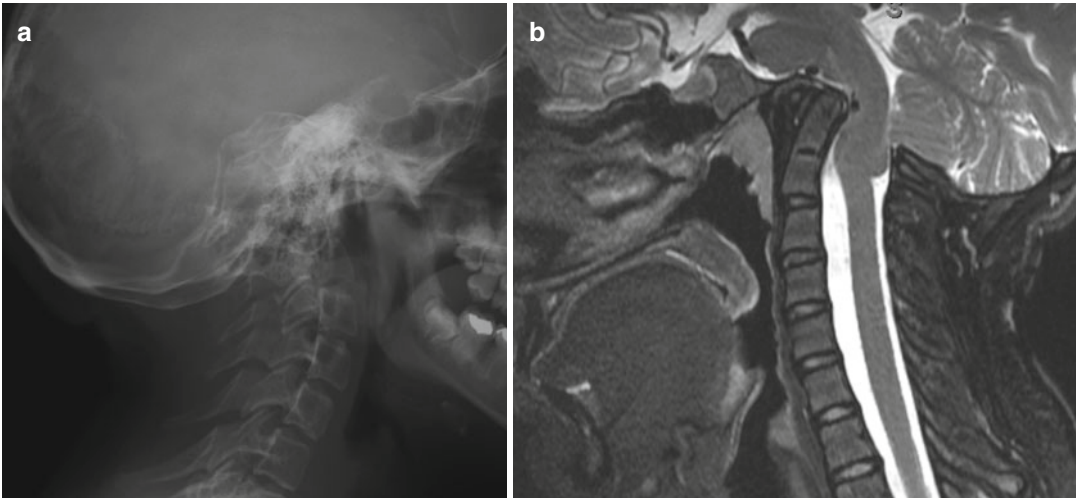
Basilar invagination in a patient with type IV OI on plain radiographs (a) and MRI (b). The patient is asymptomatic
